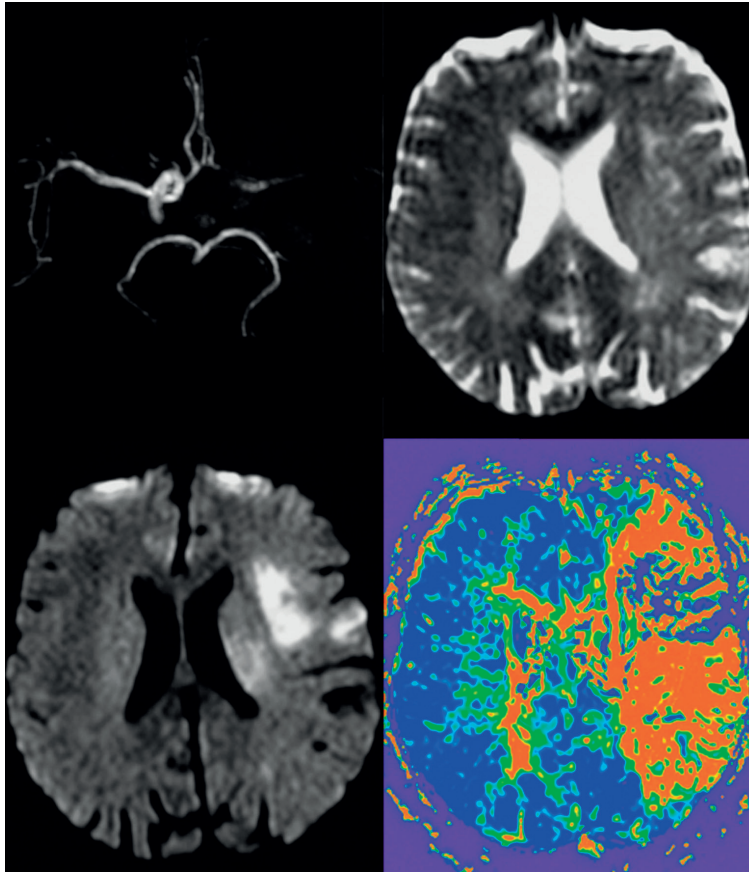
Patient presenting 3.5 hours after symptom onset with aphasia and right hemiparesis. There is distal occlusion of the internal carotid artery and proximal middle cerebral artery occlusion on the left (upper left). On T2-weighted images (upper right) mild hyperintensity is seen in the deep left frontal white matter. The DWI abnormality is much more prominent (lower left). The PWI shows disturbed perfusion in the entire left middle cerebral artery territory (lower right). Following intravenous thrombolysis, the middle cerebral artery became patent again. The final infarction was slightly larger than the DWI abnormality. The neurologic symptoms improved.
